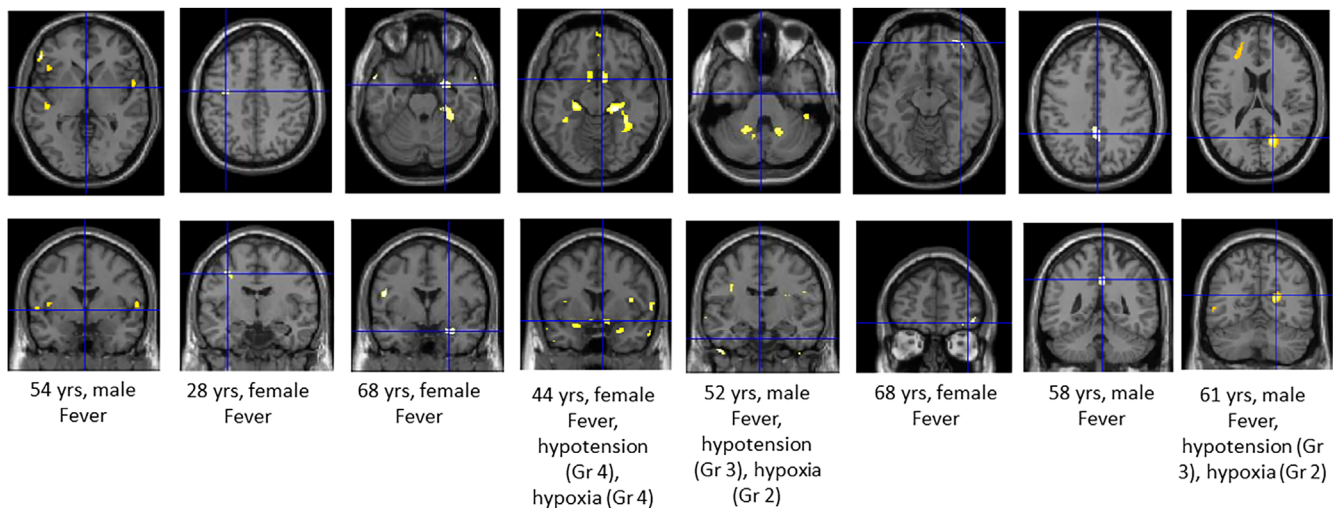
Single subject analyses comparing brain metabolism in cytokine release syndrome patients with respect to controls. A p -value of $<.001$ was accepted as significant for the single-subject analyses. Clusters with significant hypometabolism are shown superimposed on an MRI template. Gr, grades (grade 1: mild toxicity; grade 3: severe toxicity); MTV, metabolic tumor volume; TLG, total lesion glycolysis; yrs, years.
